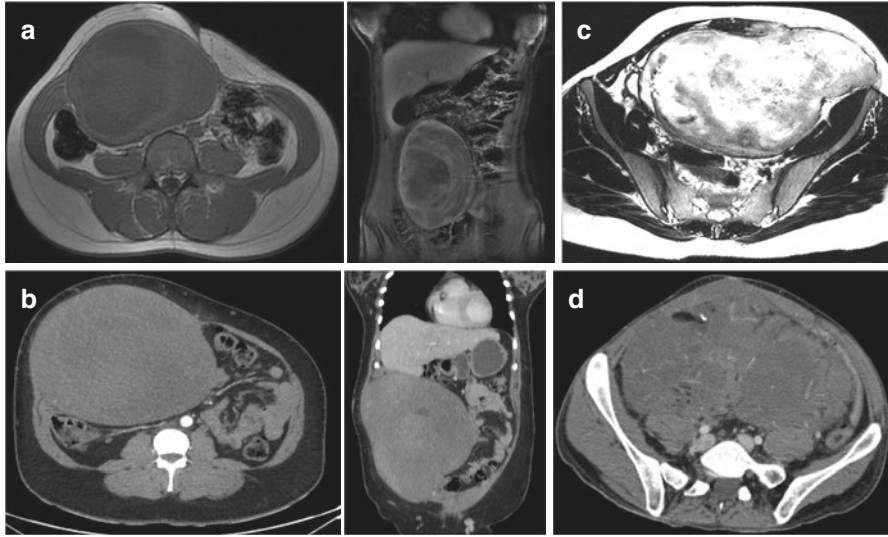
Examples of desmoid fibromatosis. The lesions can reach a large volume and generate diagnostic doubt. The MRI brings additional information to the CT, as it allows to evaluate the cellularity and the fibrosis content, which helps in monitoring the response to drug treatments. (a, b) DF originated in the abdominal wall and protruded into the peritoneal cavity. (c) Example of pelvic DF with hypersignal on MRI, suggesting active disease and hypercellularity. (d) Extensive DF of mesentery in a patient with familial adenomatous polyposis
